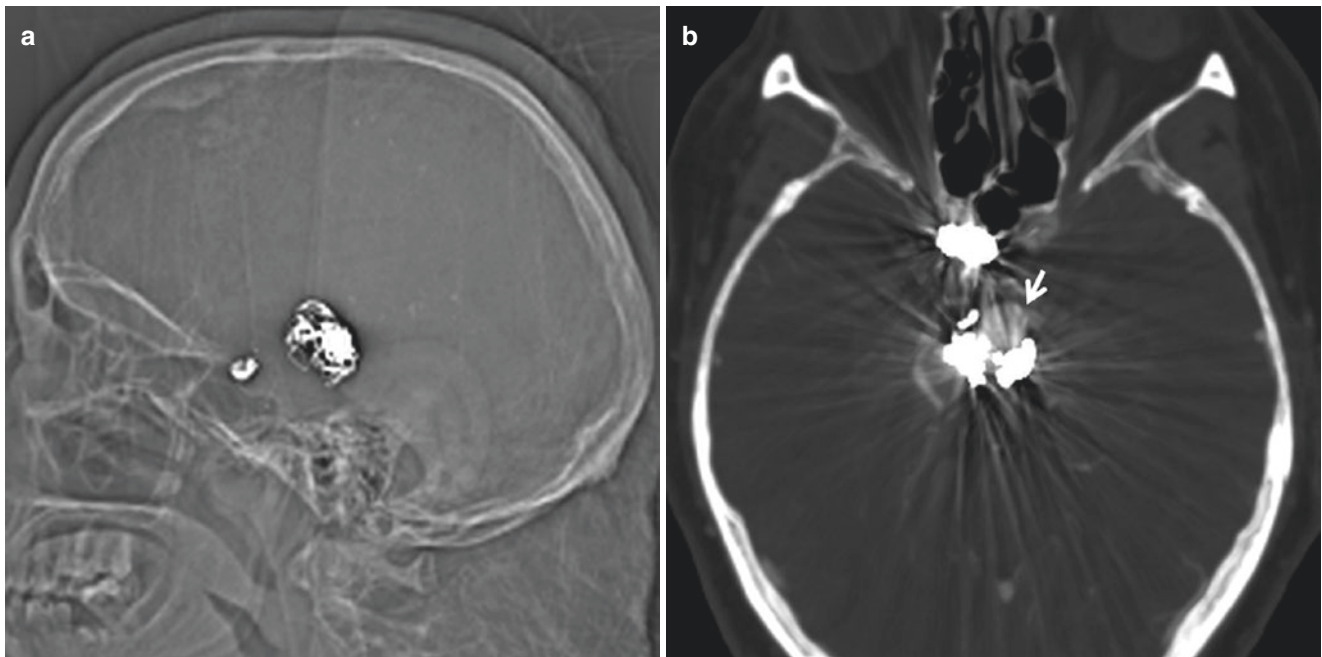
Recurrent aneurysm after coiling. Patients with remote history of aneurysm coiling present with acute headache and weakness. (a) Lateral CT scout of the head reveals two coil masses in the expected regions of basilar artery and supraclinoid ICA, both of which show evidence of coil compaction. (b) Axial CTA with limited image quality
